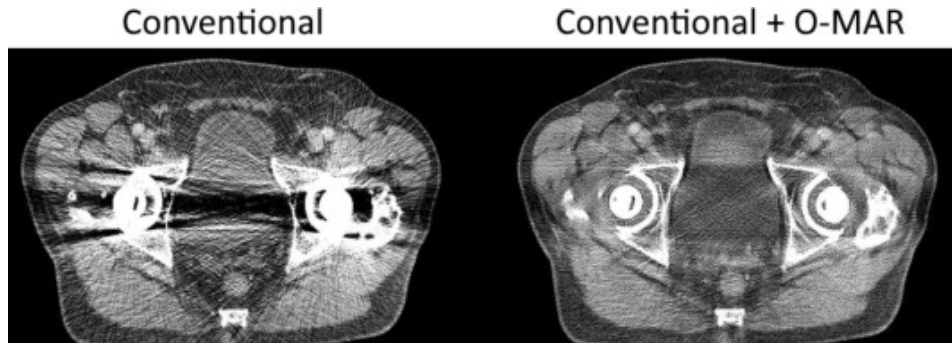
CT scan with bilateral hip arthroplasty demonstrating the effect of metallic implants (left) and metal artifact reduction with (right). The left image exhibits pronounced dark and bright streaks, a result of beam hardening and photon starvation, which obscure the implant and surrounding tissue. The right image shows a marked reduction using an iterative sinogram-based metal artifact reduction algorithm (O-MAR). Figure adapted from [48].
